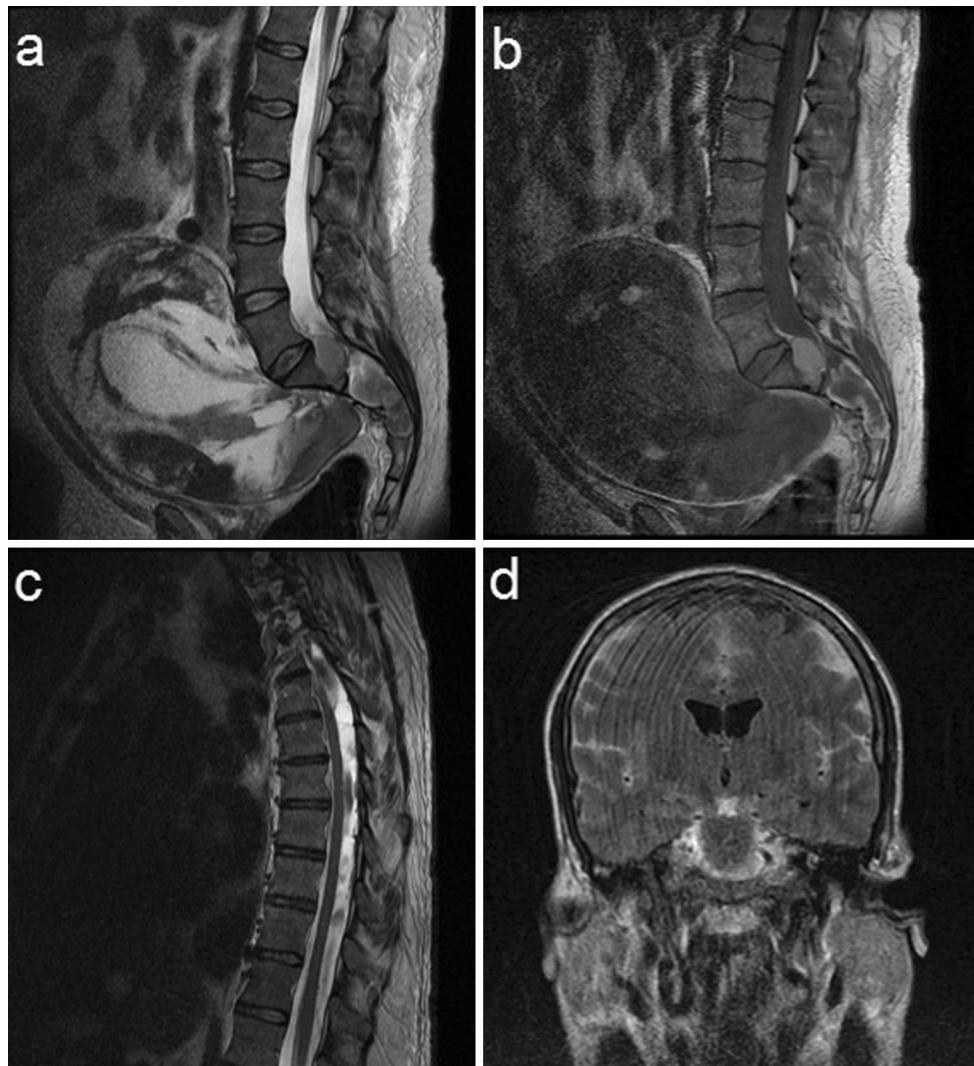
Different MRI cuts show a presacral mass, measuring $20 \times 16 \times 14$ cm, with apparently no elements inside the cyst, hyperintense in T2 (a) and hypointense in T1 (b) with images of intralesional bleeding and clear communication with the spinal canal
